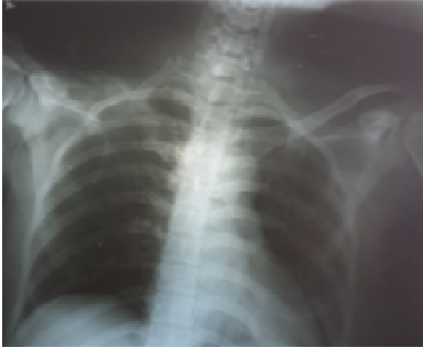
Chest radiograph after surgical resection of the clavicle.
